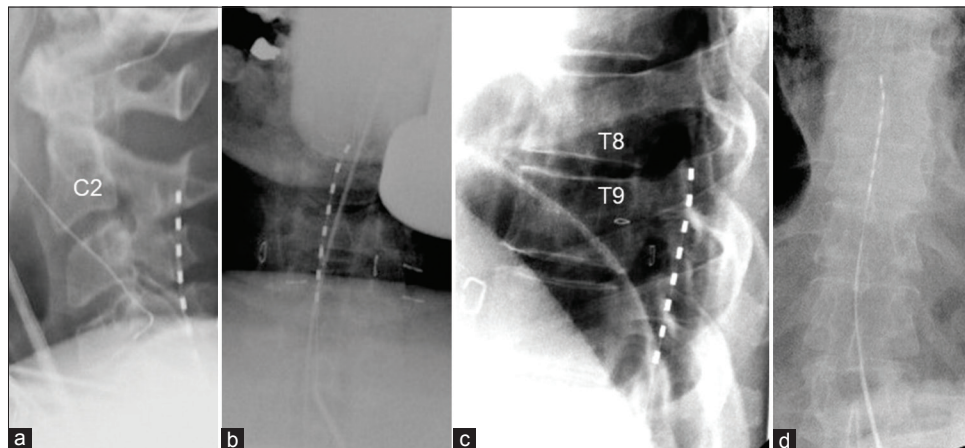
Postoperative lateral (a) and posterior-anterior (b) radiographs of cervical spinal cord stimulator lead placement at C2 and lateral (c) and posterior-anterior thoracic lead placement at T9 (d).
